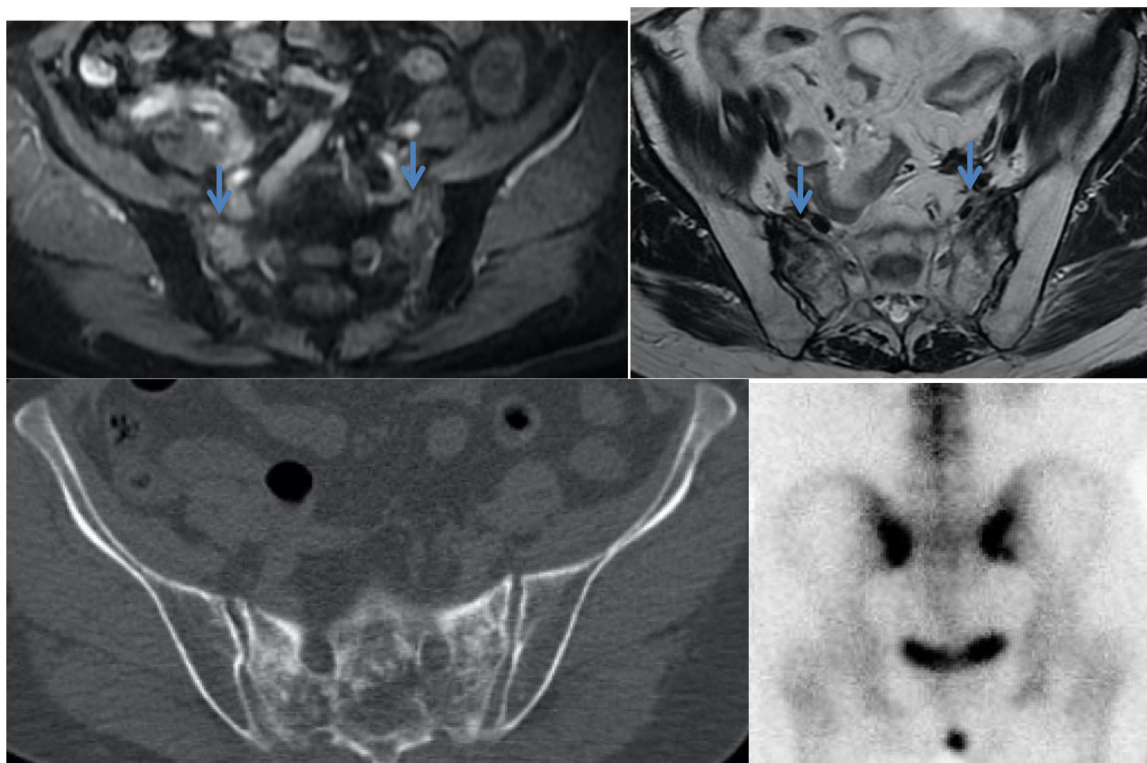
Case 2. Contrast material accumulation zones and uneven hypointense signal in T1 sequence on MRI images (blue arrows). Bone scintigraphy showed atypical “H” sign and inhomogenous osteosclerosis is seen on CT images. (Color version of figure is available online.)
